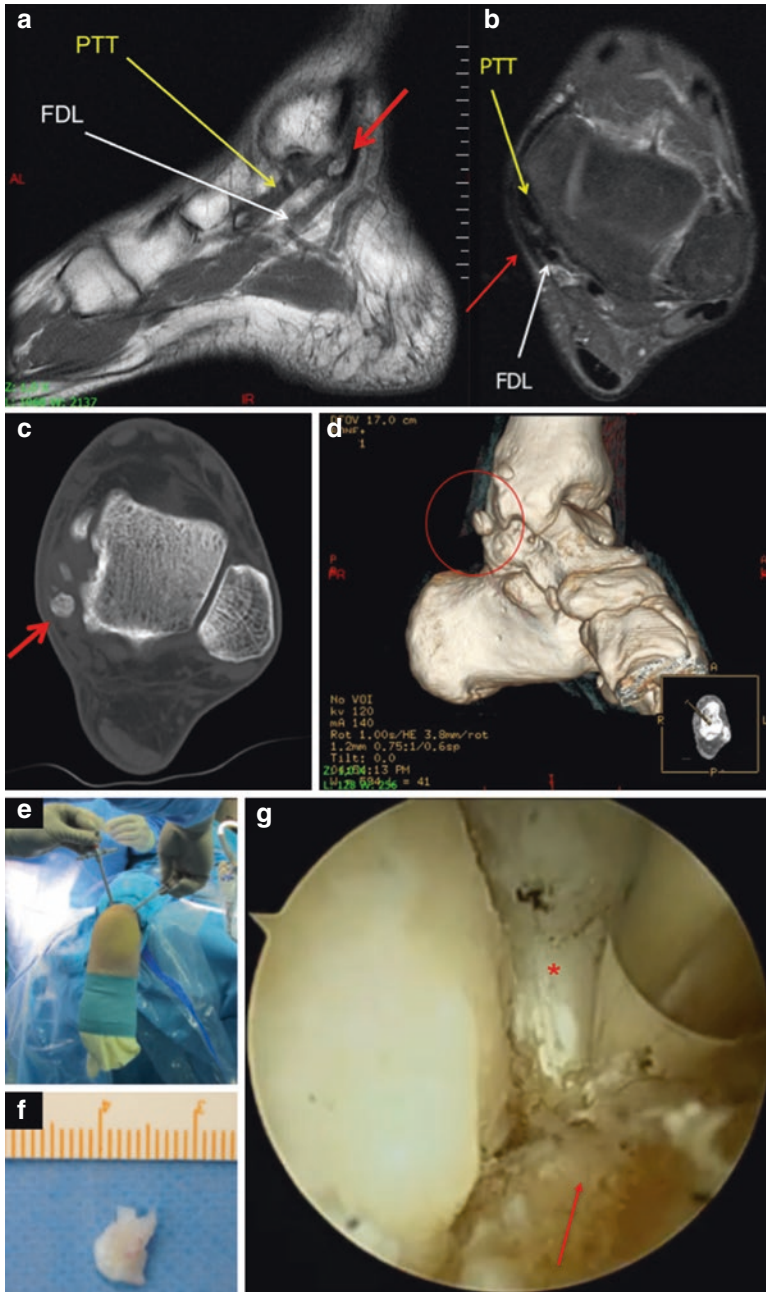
(a and b) represent MRI views (sagittal and axial, respectively) of posterior tibial tendon (PTT) and flexor digitorum longus (FDL). (c and d) show CT axial and 3D images. Red arrows and red circle indicate bone ossicle causing tendon's irritation. (e) shows posterior
